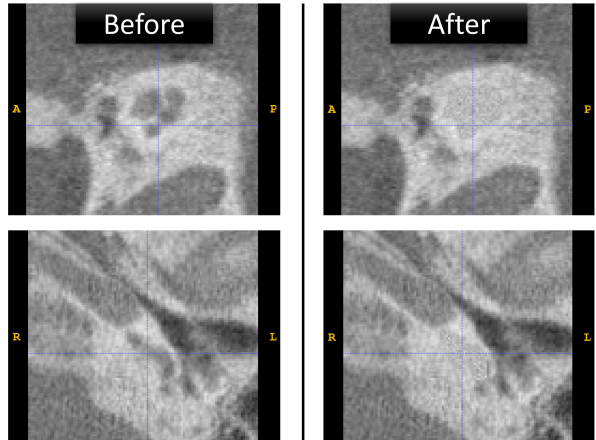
Sample CT scan from test set, before (left) and after (right) the artificial cochlea removal process.
